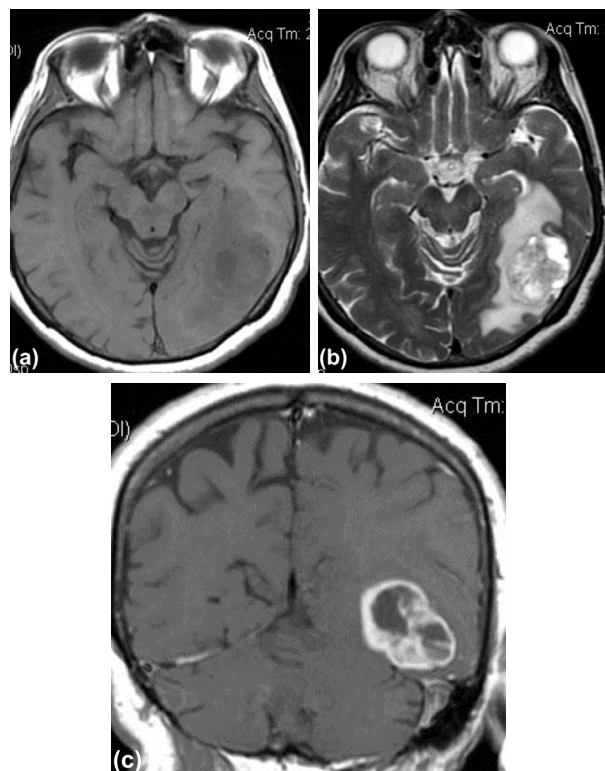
MRI shows a right occipital mass with central necrosis [(a) T1W; (b) T2W] and intense surrounding enhancement in T1+Gado (c). MRI: Magnetic resonance imaging; W: Weighted; Gado: Gadolinium.
